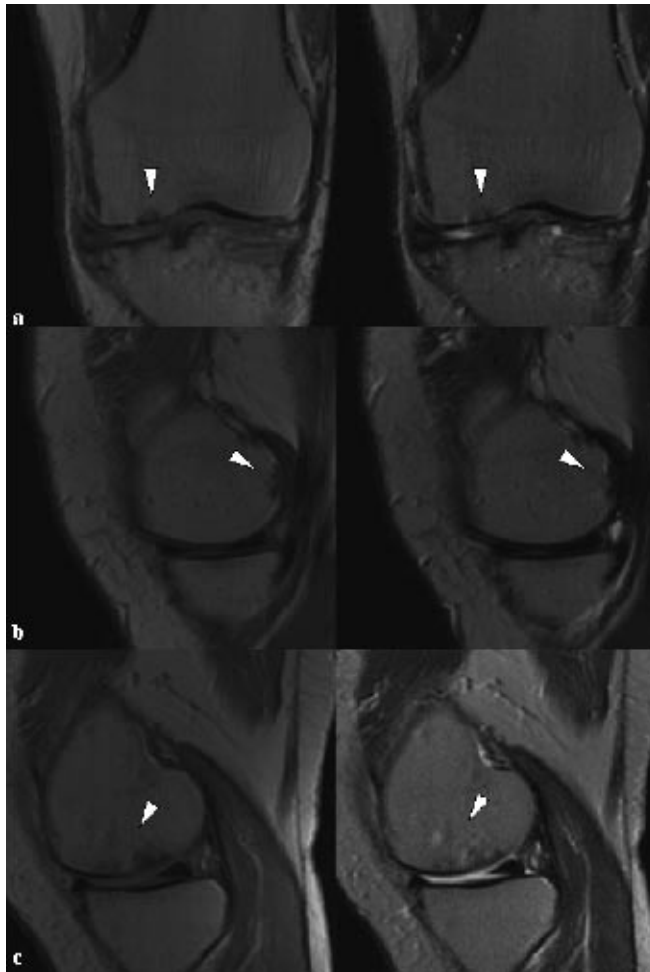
Coronal or sagittal dual spin echo MR images of different grades of bone marrow edema (arrowheads): A grade 1; B grade 2; C grade 3
